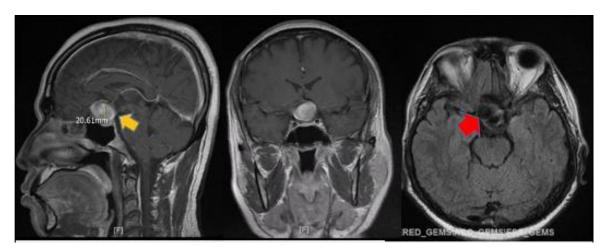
Magnetic resonance imaging of the brain revealed a saccular aneurysm on the medial side of the left ICA pars C7 (neck width: 0,4 cm; dome height 2,5 cm; dome width: 1,9 cm) (yellow arrow), compressing the optic chiasm (red arrow).
